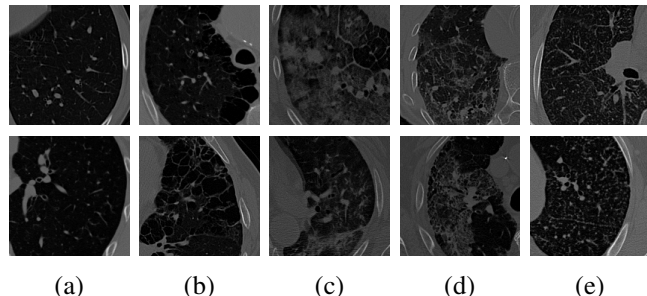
Two example images (part of original CT slices) are shown for each tissue category. (a) Normal. (b) Emphysema. (c) Ground glass. (d) Fibrosis. (e) Micronodules.
